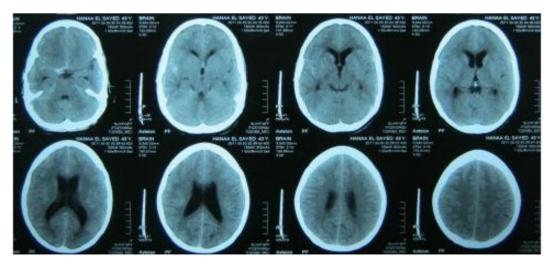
Plain CT brain shows SAH centered on the site of beginning Rt PCOM artery.
